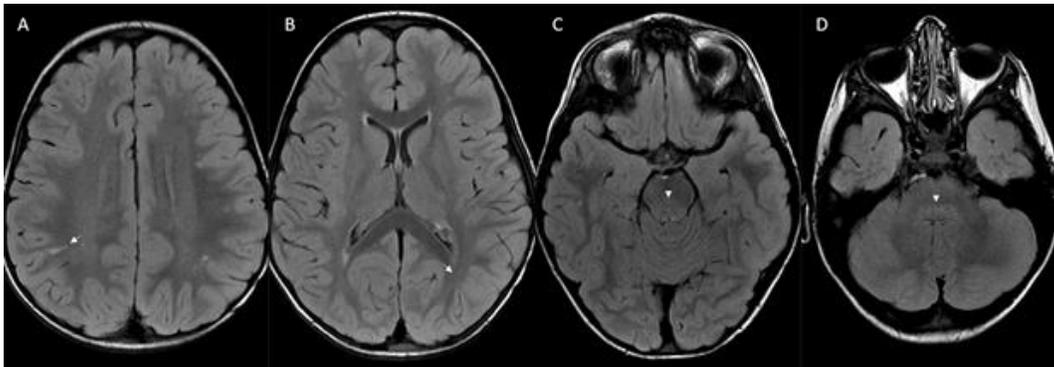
Brain MR imaging on day seven of hospitalization. Axial T2-weighted FLAIR image at the level of the centrum semiovale shows resolving bilateral punctate subcortical white matter hyperintense signals with persistence (white arrow) of signal changes in the right parietal region (A). Axial T2-weighted FLAIR image at the level of basal ganglia shows resolving abnormal bilateral punctate subcortical white matter hyperintense signals, most notably at the left parieto-occipital region (white arrow) (B). Axial T2-weighted FLAIR image at the level of rostral pons shows resolving subtle abnormal hyperintense signal (arrowhead) in dorsal pons (C). Axial T2-weighted FLAIR image at the level of caudal pons shows resolving abnormal hyperintense signal (arrowhead) in dorsal pons (D).
